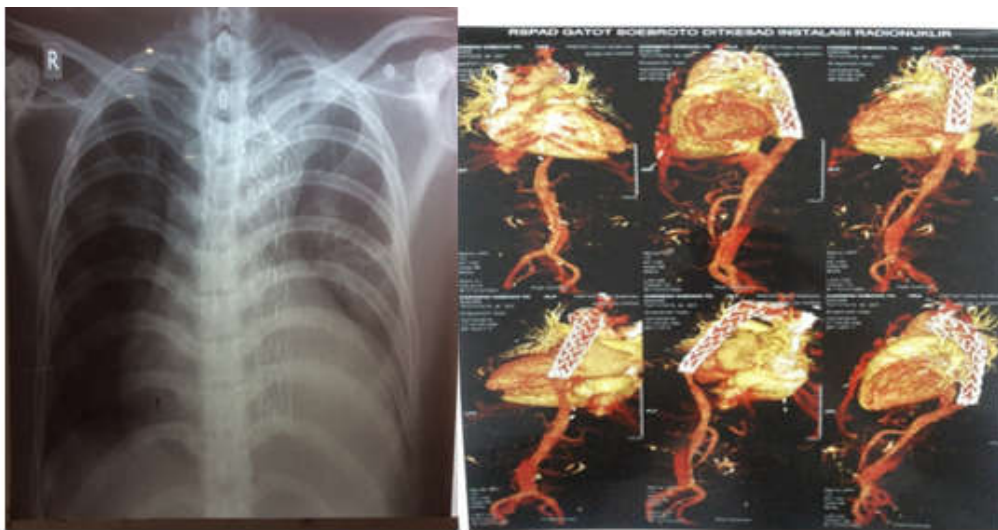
Chest X-Ray post TEVAR (right) MRI post TEVAR (left)
